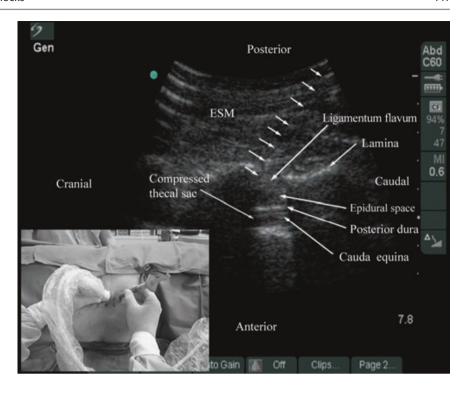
Paramedian oblique sagittal sonogram of the lumbar spine showing the sonographic changes within the spinal canal after the "loss of resistance" to saline. Note the anterior displacement of the posterior dura, widening of the posterior epidural space, and compression of the thecal sac. The cauda equina nerve roots are also now better visualized within the compressed thecal sac in this patient. Picture in the inset shows how the Episure<sup>TM</sup> AutoDetect<sup>TM</sup> syringe was used to circumvent the need for a third hand for the "loss of resistance." (Reproduced with permission from www. aic.cuhk.edu.hk/usgraweb)
